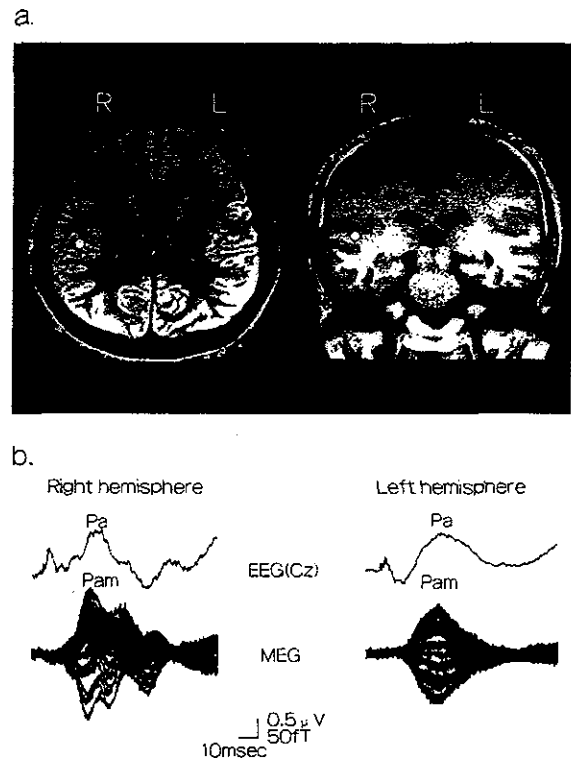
(a) Superimposition of the ECD on the auditory cortex of the brain MRI scan. A white circle indicates the localization of the ECD. (b) Typical simultaneous recordings of AMLRs and MLAEFs in a normal subject, a 25-year-old male. Right- and left-hemisphere recordings were made with contralateral stimulation.
